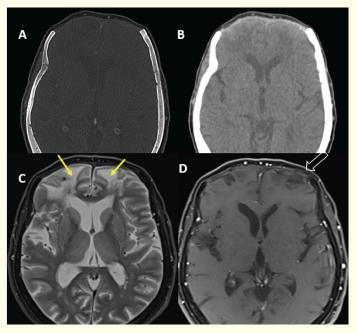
Figure 3A,B,C,D: Post-operative CT and MRI from the same level. Axial non-enhanced CT in bone and soft tissue window (A and B) - shows expected post bicoronal bifrontal creniectomy changes. No soft tissue thickening or collection at the surgical bed. Prefrontal soft tissues are normal. No intracranial collection. Axial MRI T2W and post-contrast FAT SAT T1W images (C and D) shows bifrontal gliotic changes (Yellow arrows). Prefrontal scalp soft tissues are normal. No abnormal parenchymal enhancement seen on T1W post gadolinium with fat saturation (open arrow).
